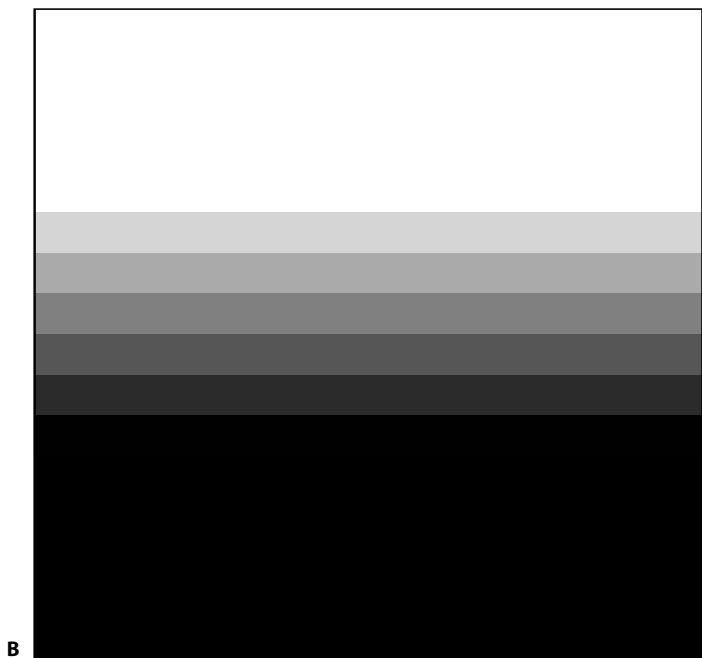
A. Radiograph performed at 50 kVp. Note the image contrast. B. Short-scale contrast, typical of radiographs performed at low kilovoltage.
